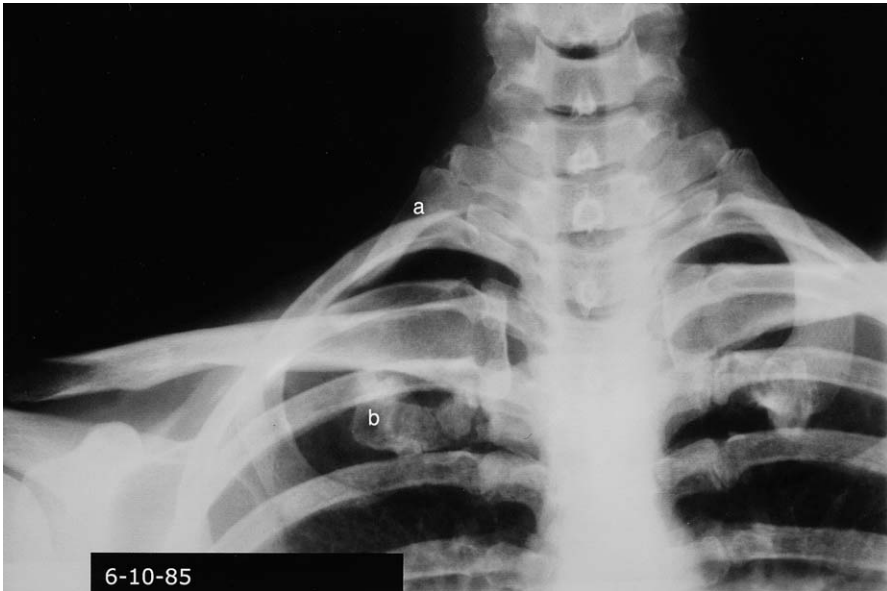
This female patient had only one third of the middle section of the right first rib removed. She had no relief of her lower type TOS. Radiograph shows 1.5-inch long right first rib remaining posteriorly (a) and 1-inch long anteriorly (b). (From The Christine M. Kleinert Institute for Hand and Microsurgery, Inc.; with permission.)
